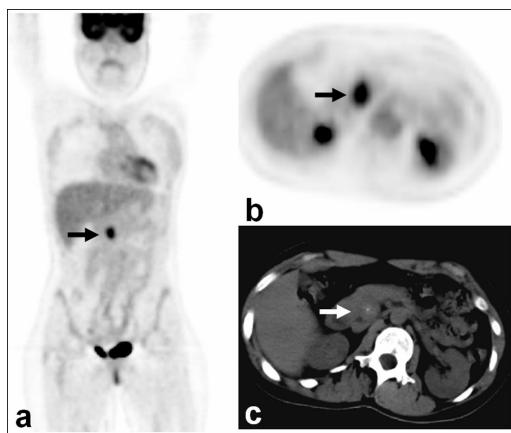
Coronal and axial F-18 FDG PET (a, b) and axial unenhanced CT (c) images showed marked degree of focal abnormal FDG uptake in the pancreatic tumor.
